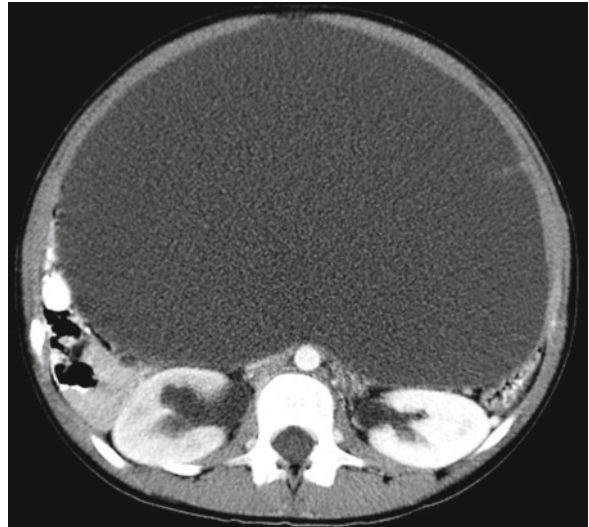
CT scan of a large cystic juvenile granulosa cell tumor
